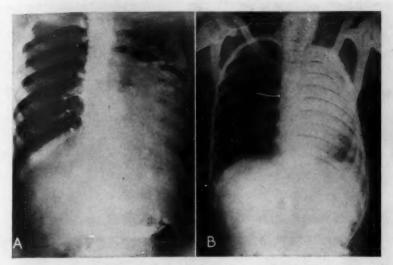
A, roentgenogram of the chest made after insufflation of an opaque medium. Almost complete basal opacity appears on the left. Patchy aeration is seen. Note sacculation of the contrast medium with some fluid levels. The right lung shows compensatory emphysema.
